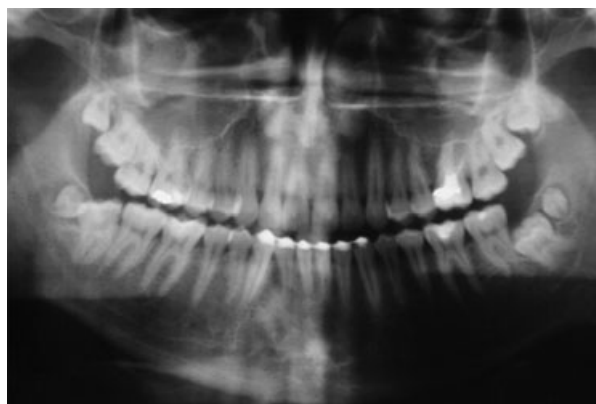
Panoramic radiograph showing the presence of four-fourth molars (distomolars), one in each hemiarch.
